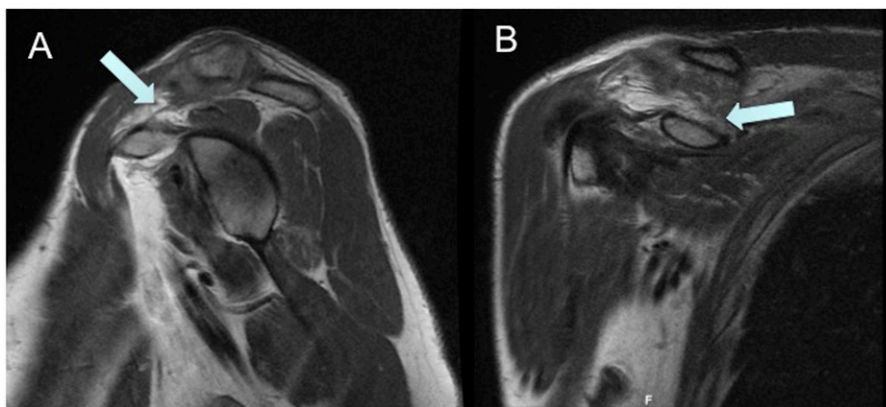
Magnetic resonance images (MRI) of a patient with type-III acromioclavicular joint injury after direct trauma. Oblique sagittal MRI (A) demonstrates rupture of the coracoclavicular ligament (arrow), which is confirmed on the coronal MRI (B.)
